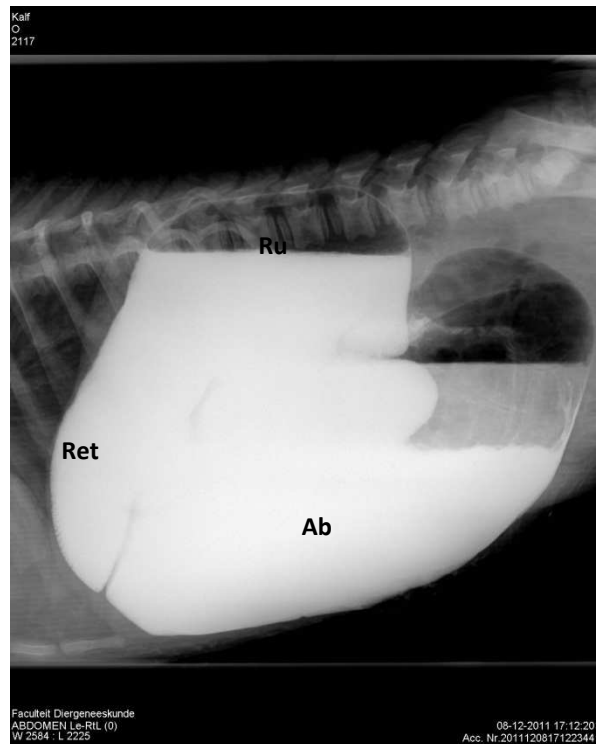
X-ray left abdominal region calf, after administering 2.1 liters of colostrum and barium-sulfate solution. Forestomachs and abomasum filled with solution of colostrum and barium-sulfate. Reticulum (Ret), rumen (Ru) and abomasum (Ab) can be distinguished.
